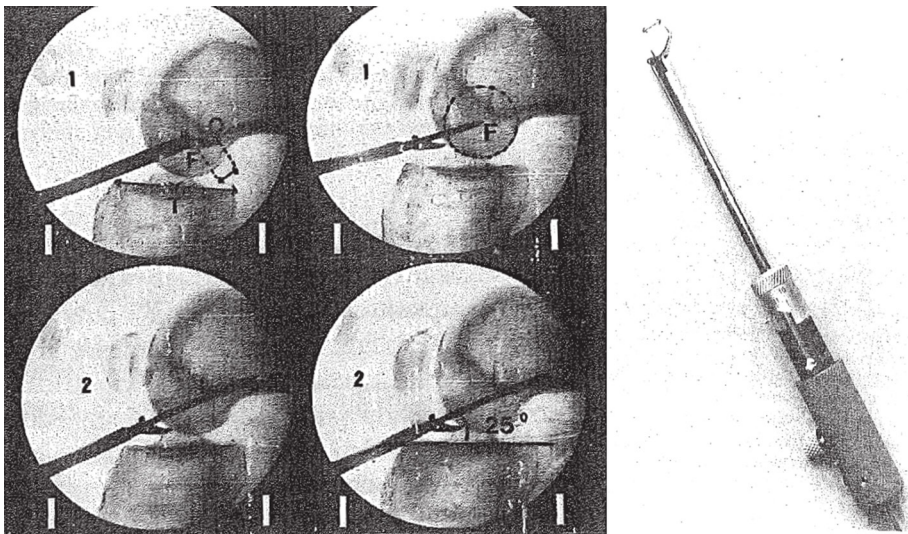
a) The distance between F and O is measured on preoperative radiographs; b) The offset distance of the femoral aimer can be adjusted to the distance FO with an adjusting knob. (With kind permission from Springer Science+Business Media: Laboureaux and Marnat-Perrichet, 1997) [46]
